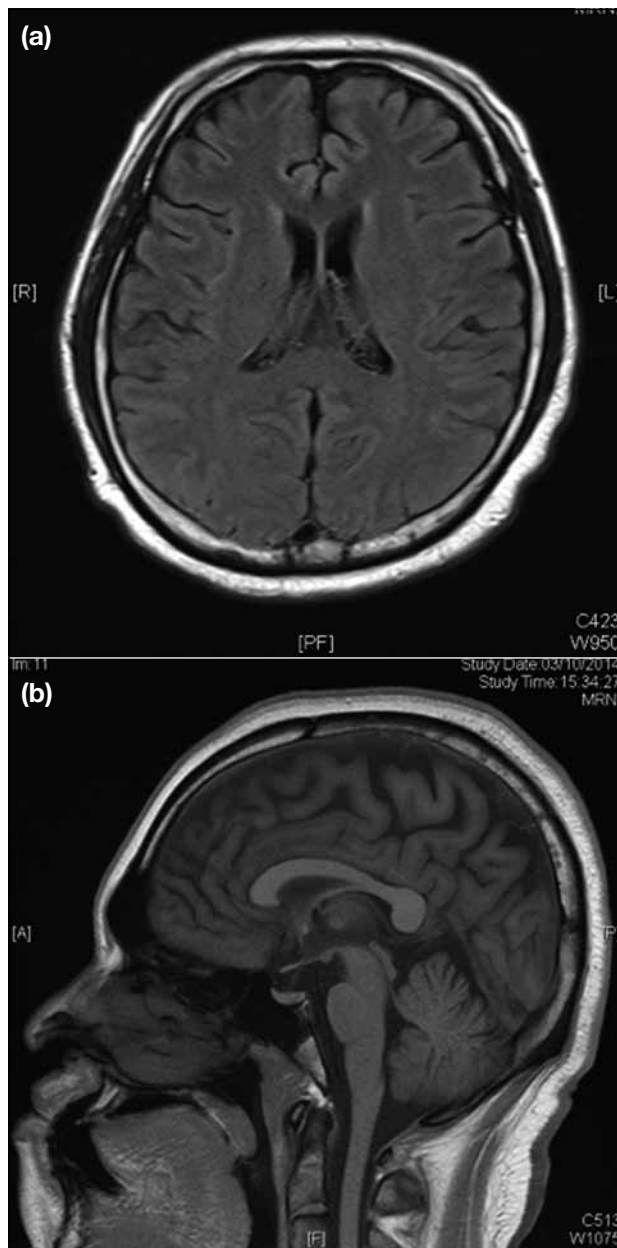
Follow-up magnetic resonance images show (a) complete resolution of the splenial lesion, and (b) resolved cerebellar swelling and normal signal intensity.
